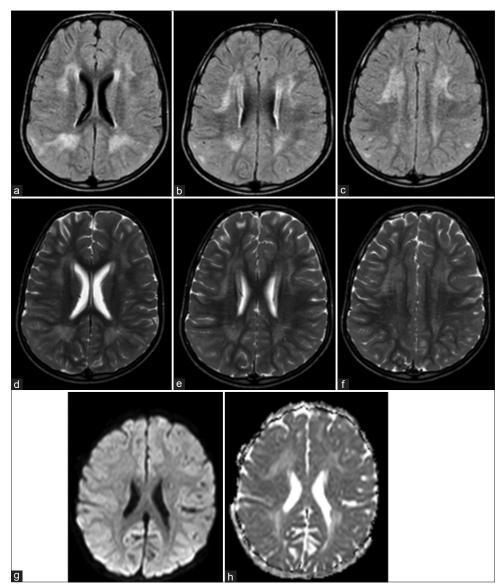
Metachromatic leukodystrophy. Bilaterally symmetrical axial FLAIR and T2W Hyperintensities (a-c, e-g) in bilateral periventricular and subcortical white matter of bilateral frontal and parietal lobes giving butterfly pattern with sparing of subcortical U fibers. On axial T2W images, perivenular sparing is seen giving tigroid like pattern. DWI (g) demonstrates no restricted diffusion associated with increased ADC (h) value
